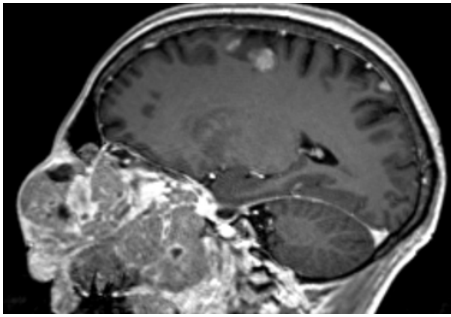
Sagittal T1 Post contrast fat sat MRI showing well defined heterogeneously enhancing mass in left nasal cavity with multiple nodular deposits in the parietal region (arrows)
